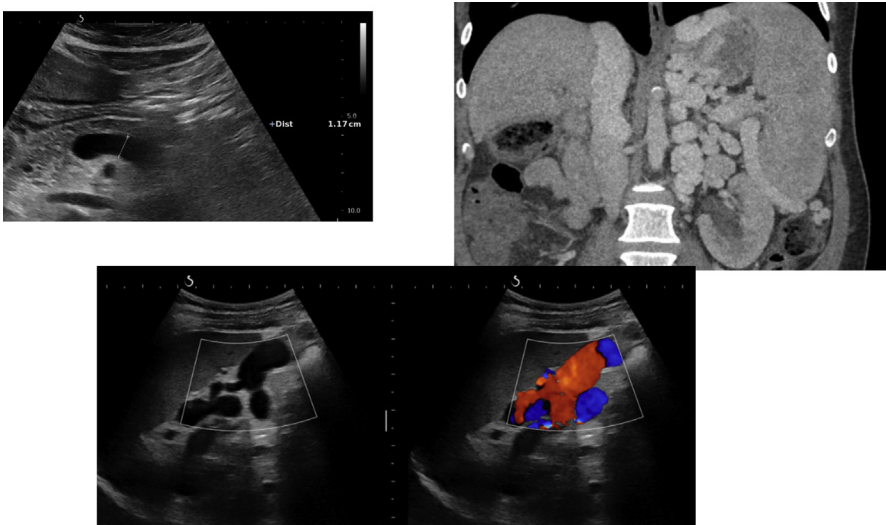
Imaging signs of portal hypertension. (*Upper left panel*) Dilatation of the splenic vein by ultrasound examination. (*Upper right panel*) Large splenomegaly and numerous large splenorenal collaterals. (*Lower panel*) Large splenorenal collaterals on conventional ultrasound examination (*left*) and color Doppler ultrasound examination (*right*).
